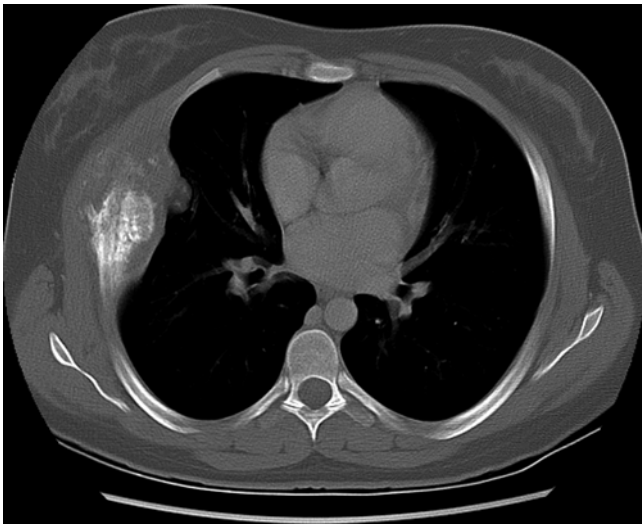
A 15 year old female presented with a 2 month history of stabbing right sided chest pain. Chest radiograph revealed a mass within the thoracic cavity and a subsequent CT scan shown here demonstrated a large mass arising from the right 5th rib with osteoid matrix and irregular well-defined margins. Initial incisional biopsy was not diagnostic, so a resection involving segments of three ribs was performed and it was shown to be an osteosarcoma
